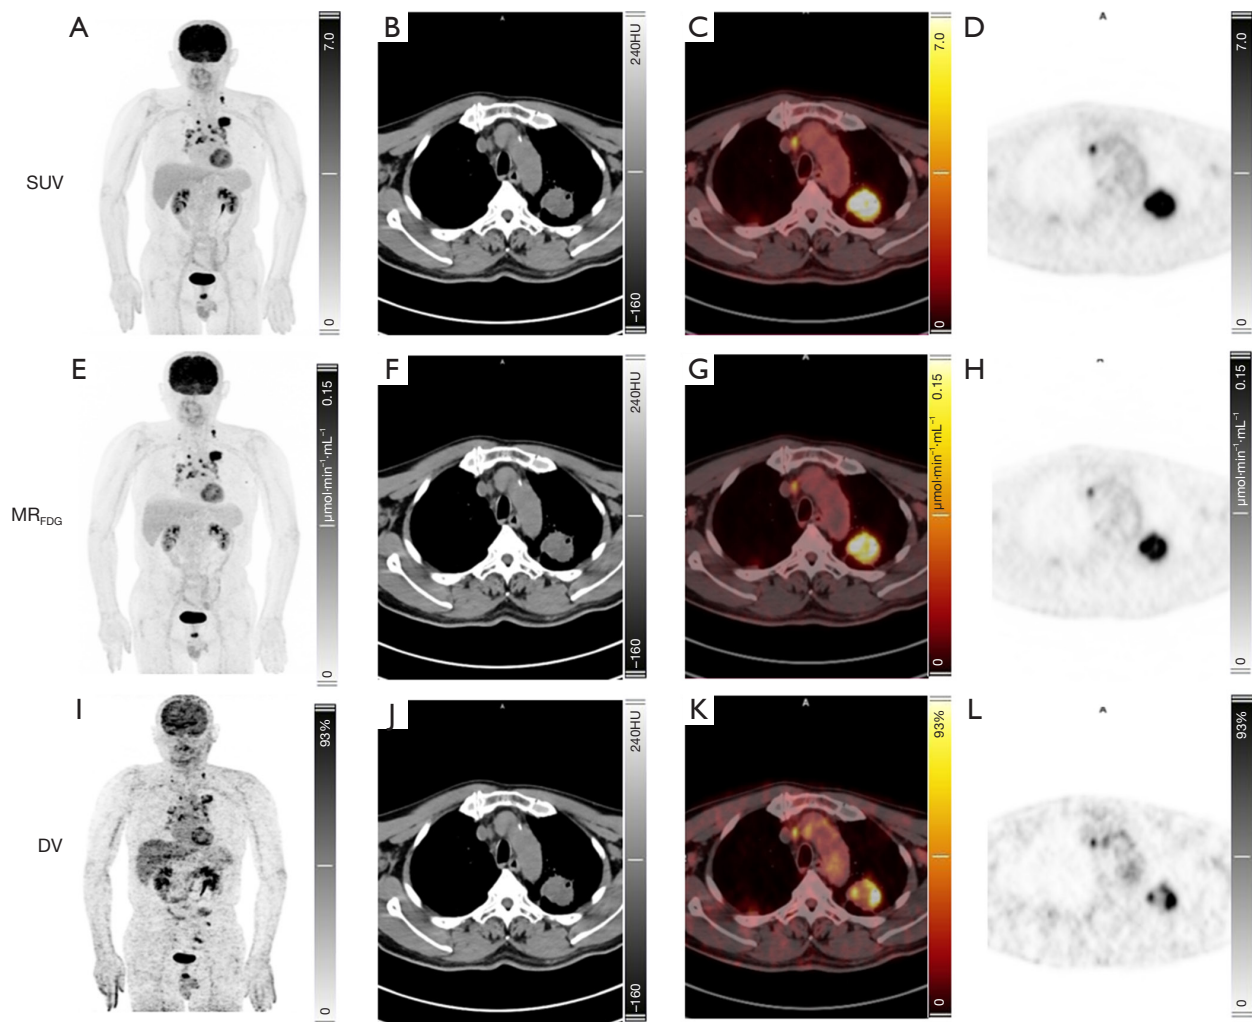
A 68-year-old man with left lung squamous cell carcinoma. First line: static SUV; the second line: MR_{FDG} images; the last line: DV images. (A) MIP of SUV image; (B) axial CT image; (C) axial fuse SUV image; (D) axial SUV image; (E) MIP of MR_{FDG} image; (F) axial CT image; (G) axial fuse MR_{FDG} image; (H) axial MR_{FDG} image; (I) MIP of DV image; (J) axial CT image; (K) axial fuse DV image; (L) axial DV image. The left upper lobe lung tumor display intense focal ^{18}F -FDG uptake ($MR_{FDG-max} = 0.44 \mu\text{mol}\cdot\text{min}^{-1}\cdot\text{mL}^{-1}$, $DV_{max} = 241.39\%$, $SUV_{max} = 16.47$, $TBR_{max-SUV} = 22.00$, $TBR_{max-MR_{FDG}} = 25.45$, $TBR_{mean-SUV} = 12.50$, $TBR_{mean-MR_{FDG}} = 14.62$, $CNR_{max-SUV} = 74.32$, $CNR_{max-MR_{FDG}} = 105.00$, $CNR_{mean-SUV} = 41.40$, and $CNR_{mean-MR_{FDG}} = 57.50$). SUV, standardized uptake value; MR_{FDG} , metabolic rate of FDG; DV, Patlak intercept; MIP, maximum intensity projection; CT, computed tomography; ^{18}F -FDG, fluorine-18 fluorodeoxyglucose; TBR, target-to-background ratio; CNR, contrast-to-noise ratio.
